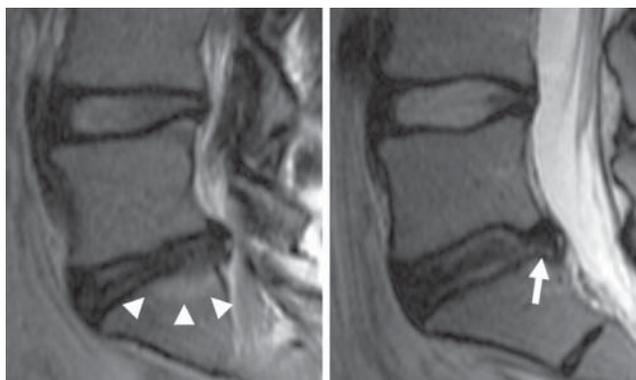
Modic type 2 change (arrowheads) and radial tear (arrow) at L5–S1 level in the same individual in T1- (left) and T2-weighted images.
